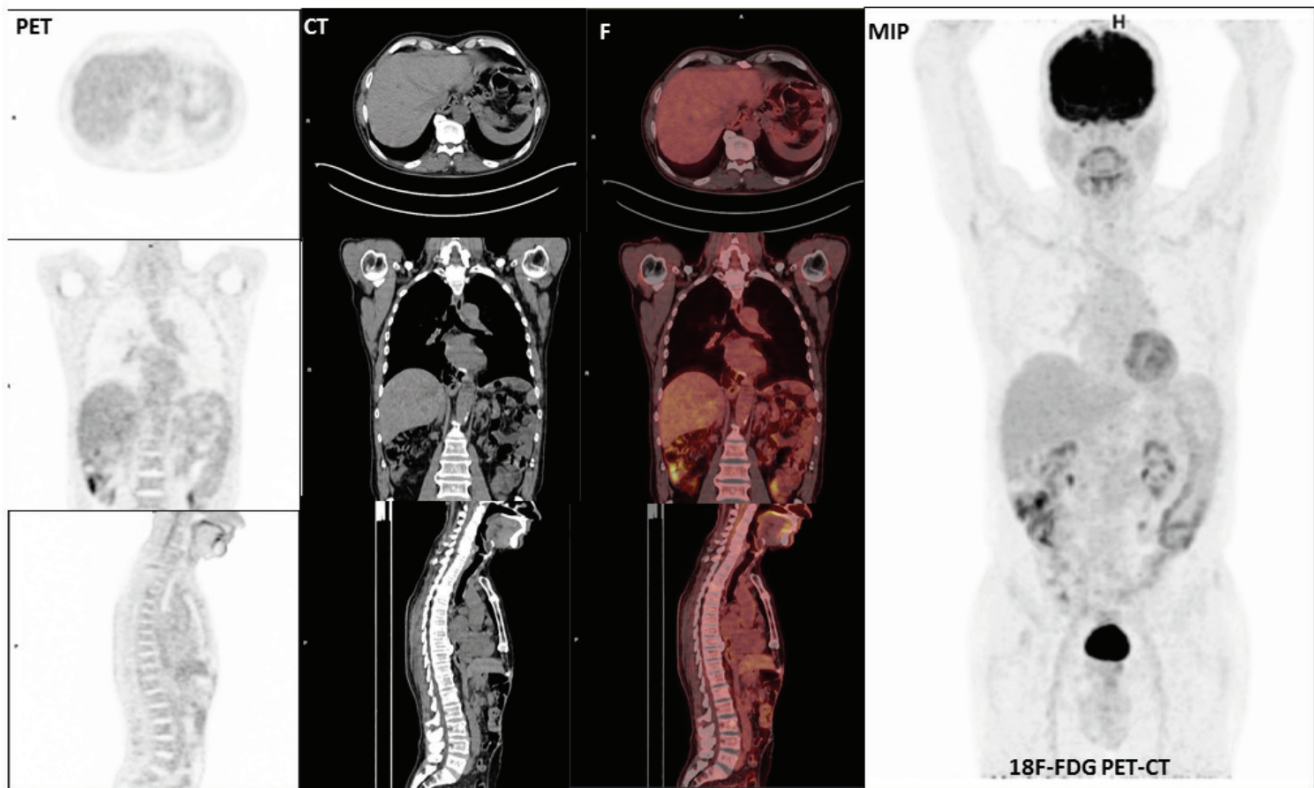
No abnormal ^{18}F -fluorine-fluorodeoxyglucose (^{18}F -FDG) uptake at the eso-jejunostomy line was detected in ^{18}F -FDG PET/CT computed tomography images.
